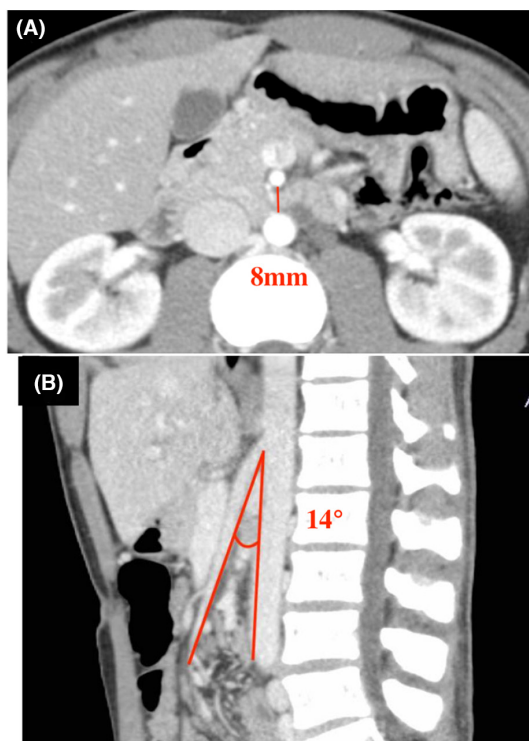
(A) Arterial phase of contrast computed tomography (CT) axial section. The distance between the aorta and superior mesenteric artery (SMA), where the duodenum passes through, is 9 mm. (B) Arterial phase of contrast CT sagittal section: SMA bifurcates at a 14° angle from the aorta.
